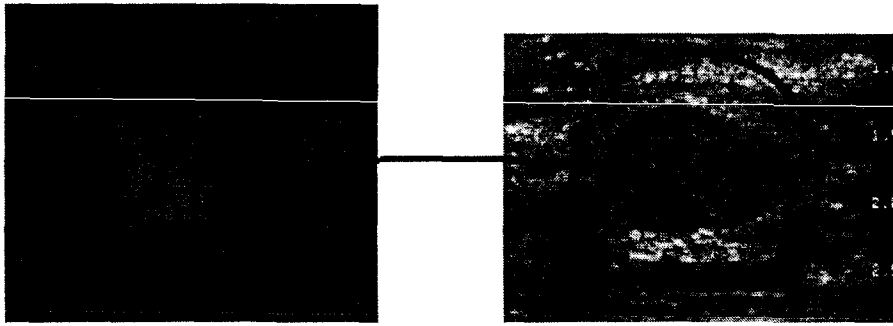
Mammogram and ultrasound view of a breast mass.
